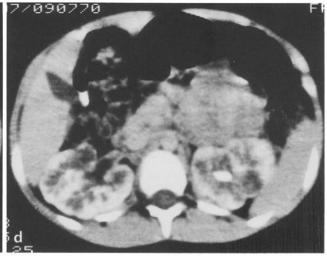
Children with RPKD. a The neonatal IVP of patient 12 B demonstrates gross renal enlargement and accumulation of contrast medium in dilated tubules. b US of patient 13 A at 7 years shows increased renal echogenicity which exceeds that of liver, obscure contour and no detectable cysts. c CT of patient 13 B at 7 years shows lace-like medullary cysts and accentuation of contrast medium in the cortex. d CT of the sporadic patient 35 A at 13 years shows findings of RPKD but with a thicker cortical rim
